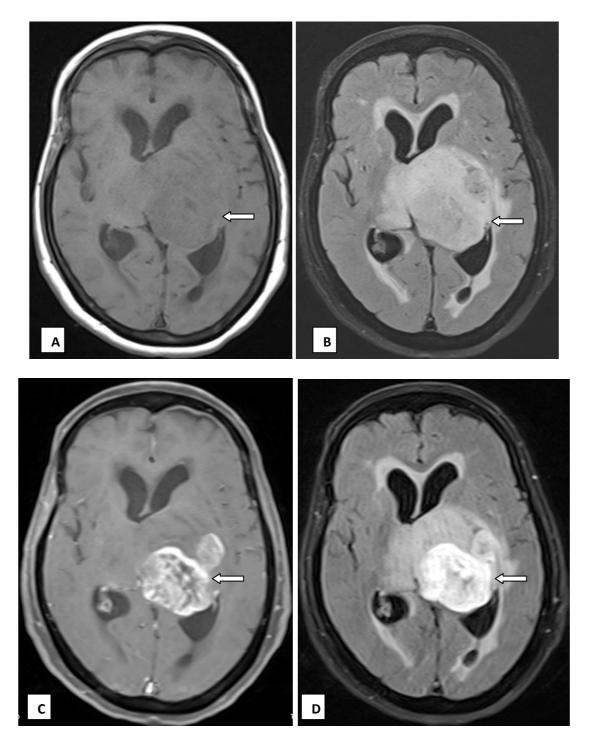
MRI Brain axial sections of 79-year-old female diagnosed with glioblastoma showing a well-defined, T1 isointense (A) & (B) T2 FLAIR heterogeneously hyperintense lesion demonstrating moderate heterogeneous enhancement on (C) T1 FS PC & avid heterogeneous enhancement on (D) T2 FLAIR PC images, with peri lesional edema better depicted in the latter image.
